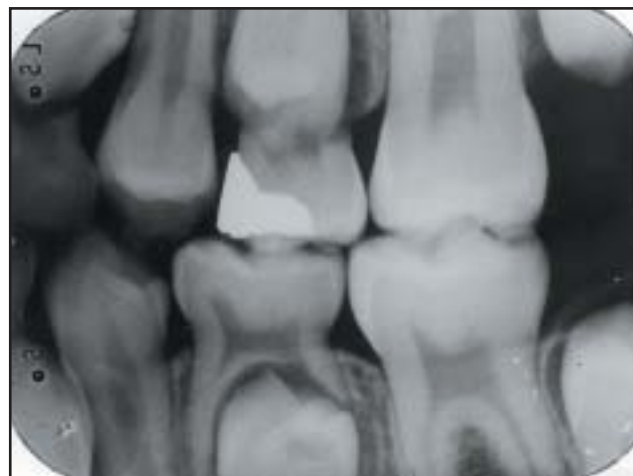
Bitewing radiograph taken one and half years prior to Figure 1. A retrospective viewing of this radiograph showed the second primary molar undergoing physiological resorption and a slightly rotated succedaneous premolar underneath. A radiolucent area was now observed on the distal part of the premolar crown. This area when compared with Figure 1 seems smaller and less radiolucent. At the time of exposure of this earlier bitewing, this finding was misdiagnosed by the clinician and was attributed as an artifact related to the rotation of the premolar.
